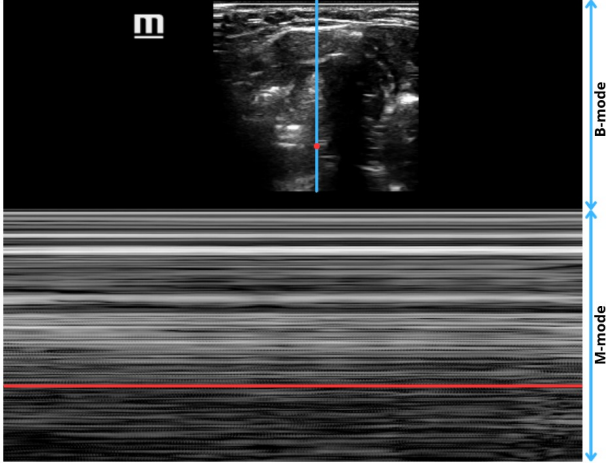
Example of B-mode (top) and M-mode (bottom) images, with M-mode recorded along a vertical line (in blue on the B-mode image); the M-mode part represents ultrasound signal values along the vertical line according to time, in the horizontal direction. The signal evolution over time corresponding to the red point on the B-mode image is displayed along the red line in the M-mode zone.
